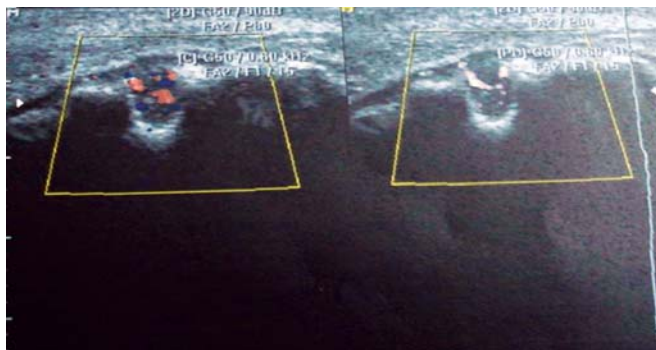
Case 1—ultrasonogram with color doppler showing vascularization
